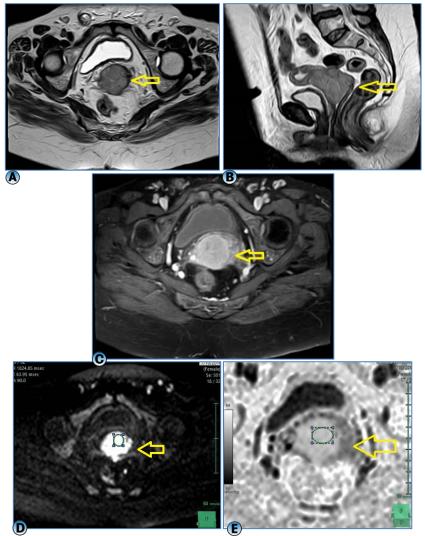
MRI (A) axial T2 WI, (B) sagittal T2 WI show mass in cervix, display moderate signal intensity, there is no interruption of the low signal stream indicating no parametrial invasion, (C) axial T1 post contrast show heterogeneous contrast enhancement, (D) DWI show restricted diffusion and (E) ADC map, ADC value $(0.85 \times 10^{-3} \text{mm}^2/\text{s})$.
